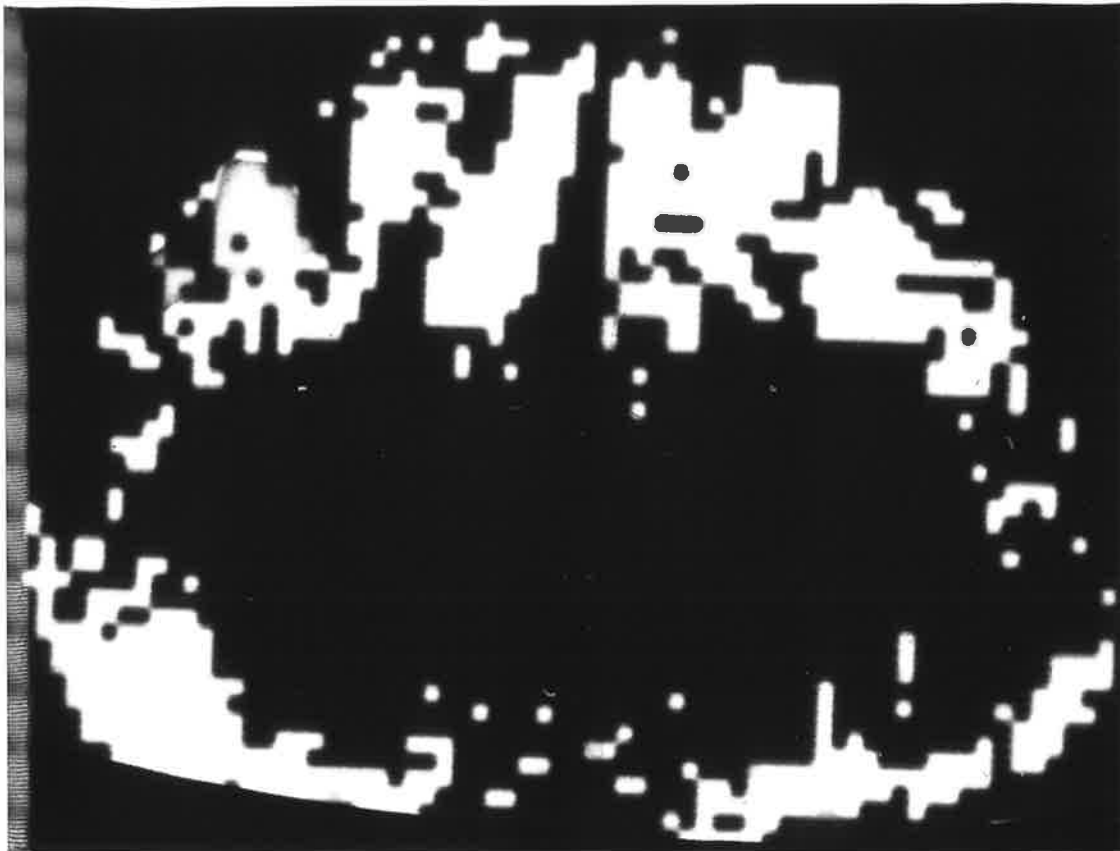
Coronal CT scans in figure 2.4.1.1 at a "measure" setting of 26 EMI units. The distribution of CM is demonstrated. The patchy brain penetration at 15 minutes (A) is related to the cortical sulci but by 60 minutes (B) relatively even distribution of the CM throughout the grey matter has occurred.
